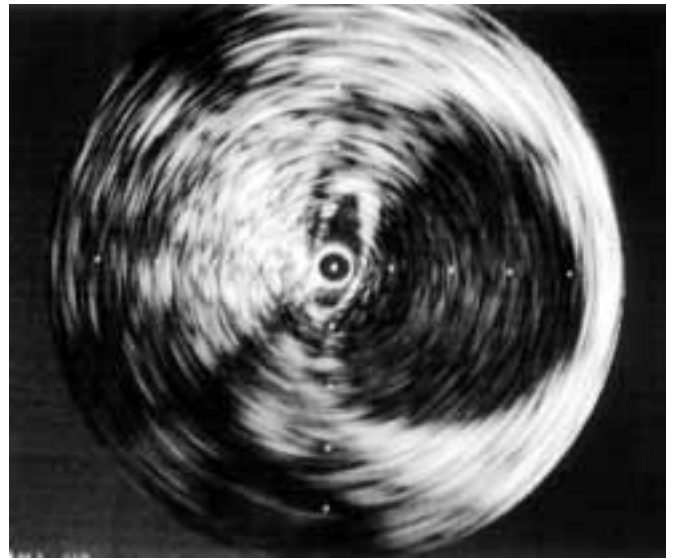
Intravascular ultrasound (IVUS) shows a stenotic dissection of the left iliac artery with total thrombosis in the false lumen until the level of the inguinal ligament.
